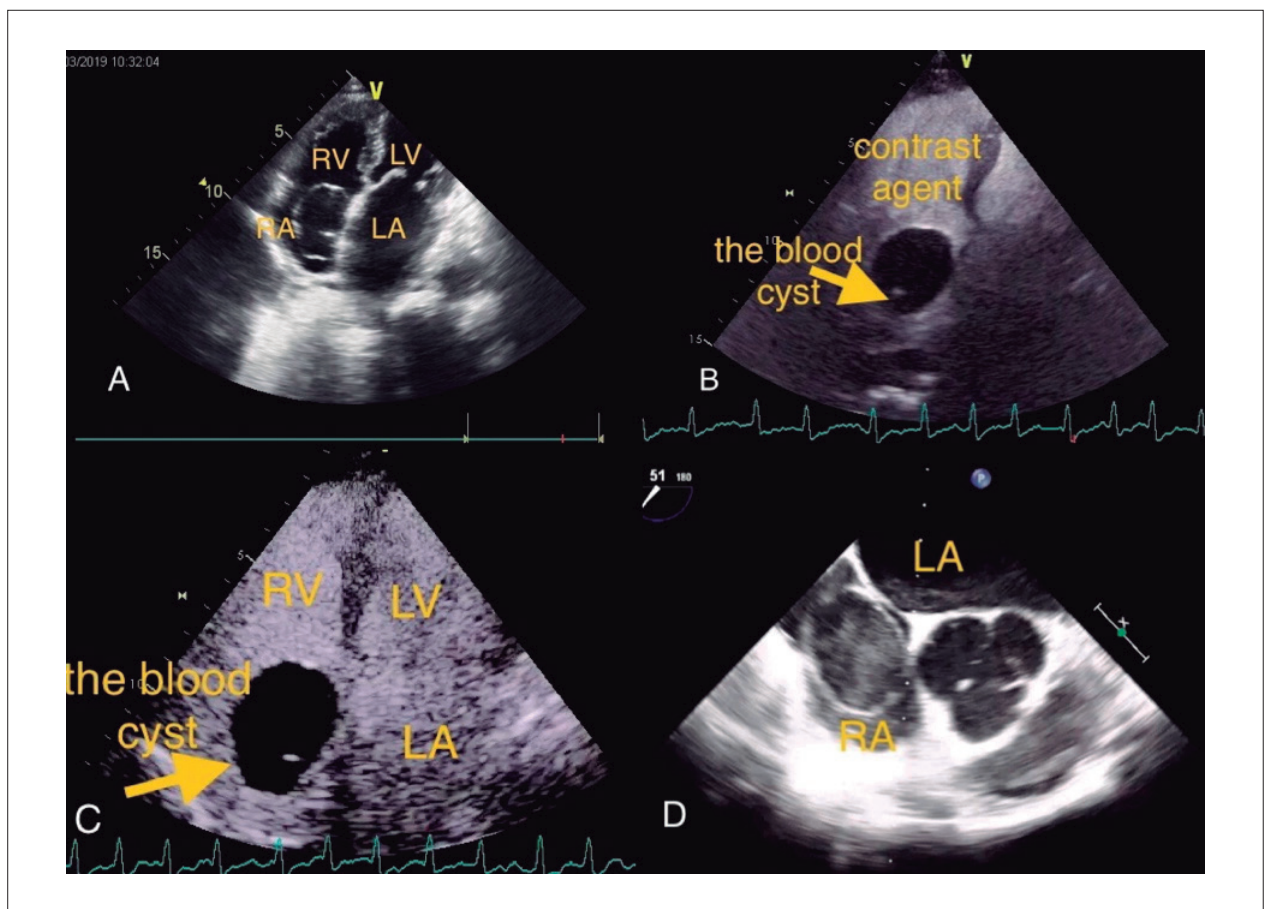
A) Transthoracic echocardiography showed a circular anechoic lesion in the right atrium. B, C) Contrast perfusion imaging showed a cystic structure with a septum and the absence of perfusion in the mass. D) Intraoperative transesophageal echocardiography revealed a circular echo in the right atrium, with spontaneous echocardiographic contrast and septation. RV: right ventricle; LV left ventricle; RA: right atrium; LA: left atrium.
